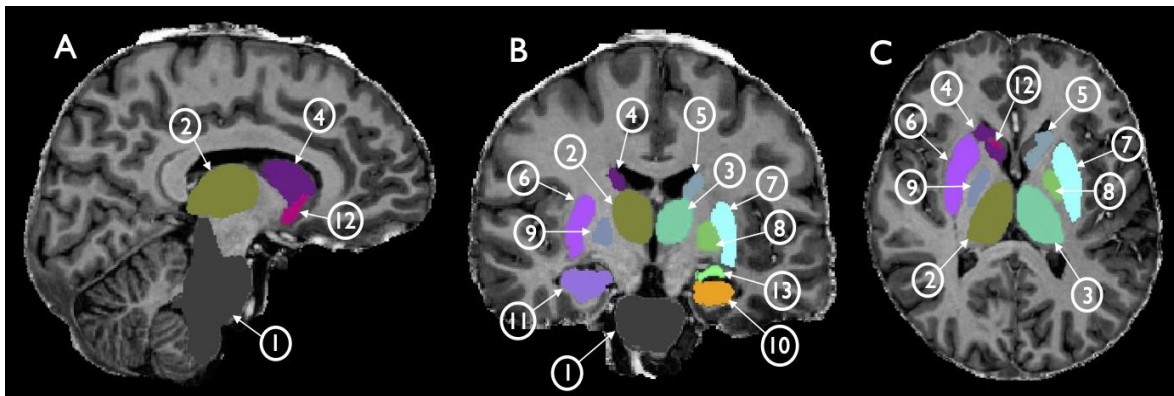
T1-weighted anatomical MP2RAGE images showing the subcortical regions included in the current study: A: sagittal view, B: coronal view, C: axial view. 1: Brain stem; 2: right thalamus; 3: left thalamus; 4: right caudate; 5: left caudate; 6: right putamen; 7: left putamen; 8: right pallidum; 9: left pallidum; 10: left hippocampus; 11: right hippocampus; 12: right accumbens; 13: left amygdala.
